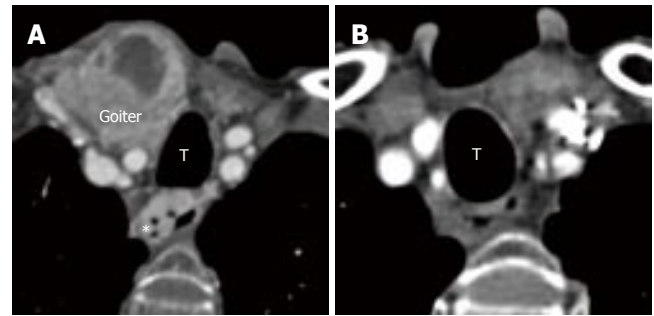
CT angiography demonstrating downhill varices one day after hemorrhage (A) and disappearance of the downhill varices 12 mo after thyroidectomy of the right lobe (B). * indicates varices around the esophagus; T, trachea.
